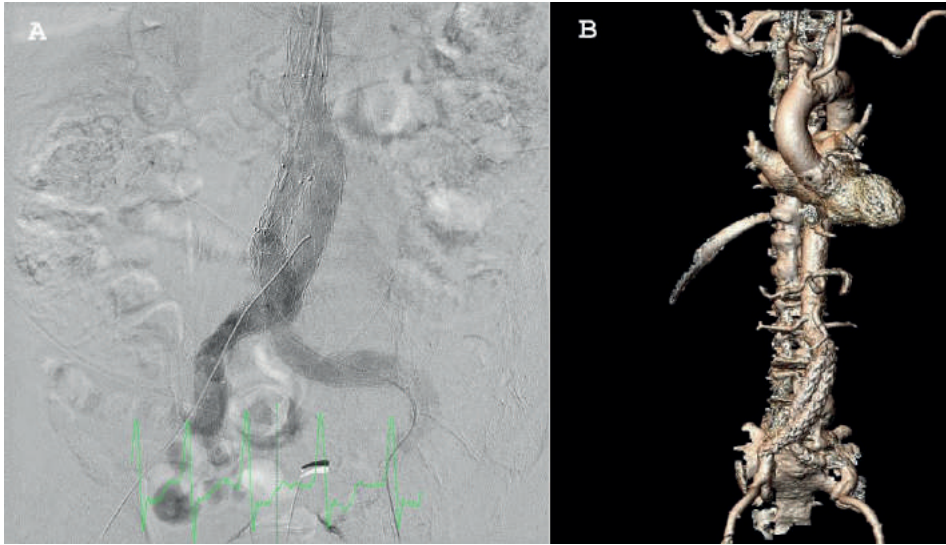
Intraprocedural and post-procedural imaging. Abdominal angiography immediately after the implantation of the aortic prosthesis just below the origin of the renal arteries (A) and three-dimensional CT reconstruction post EVAR (B).
